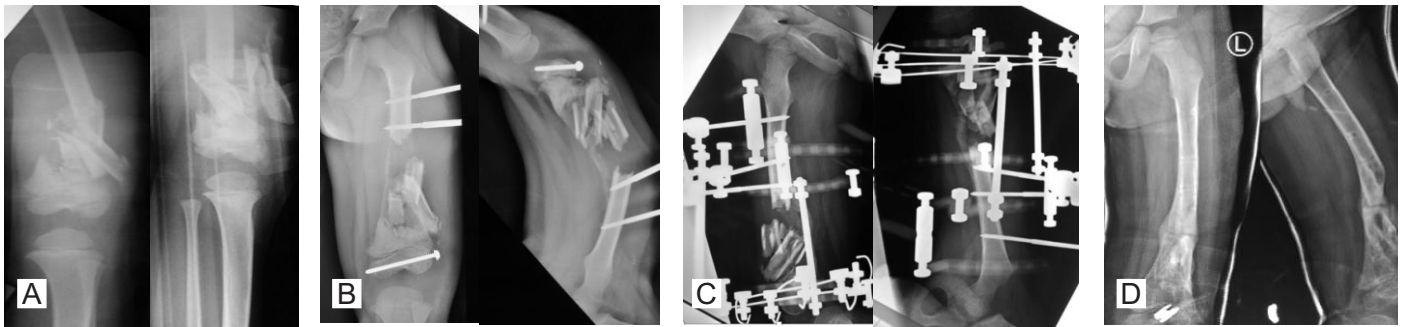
The serial radiographs of the left femur. (A) Radiograph of the left femur after the trauma showing severely comminuted fracture of the distal third with growth plate and intraarticular involvement. (B) Radiograph taken after the wound debridement and external fixation with intraarticular screw of the distal femur insertion. (C) Radiograph after Ilizarov external fixation performed approximately 3 months after the trauma (D) Radiograph done four months after the initial injury. Despite the severe bone loss noticed during the initial injury excellent bone remodelling led to fracture union. However, it was complicated by malalignment (valgus deformity) and shortening of the femur.
